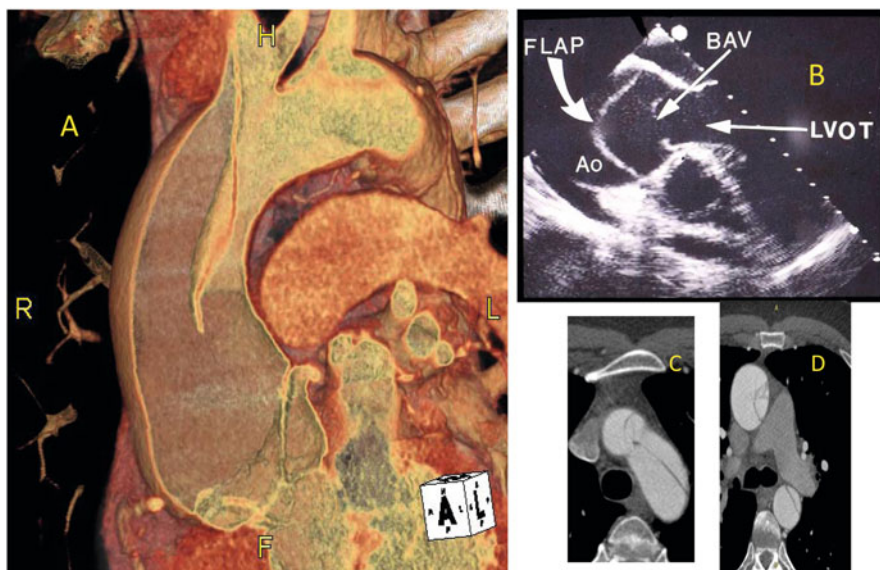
A 51-year-old male with bicuspid aortic valve aortic dissection. (a), (c), and (d) CT images and (b) echo image. *Ao* aorta, *BA* bicuspid aortic valve, *LVOT* left ventricular outflow tract
